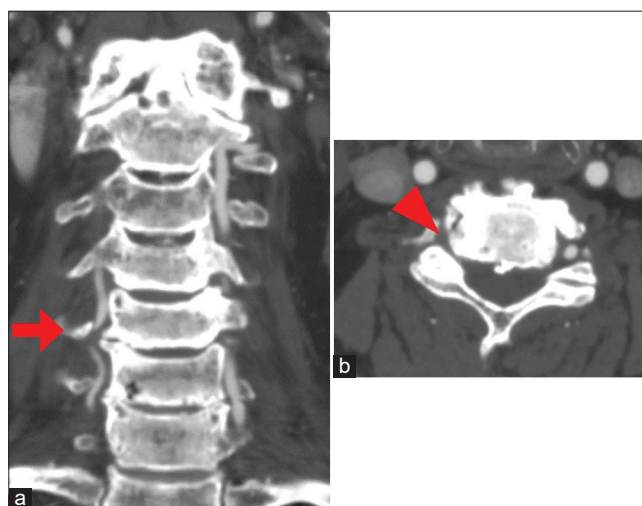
Preoperative CE-CT images. (a) Stenosis of the right VA due to compression by the bony spur at C5/6 (arrow). (b) An axial image at the level of C5/6. The right VA is not demonstrated due to transient occlusion.
